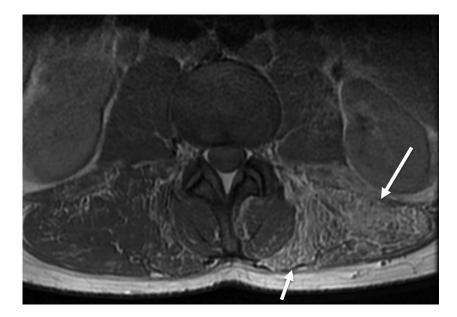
T1-weighted MRI with contrast. Left paraspinous musculature showed enhancement with contrast administration (straight arrows).
